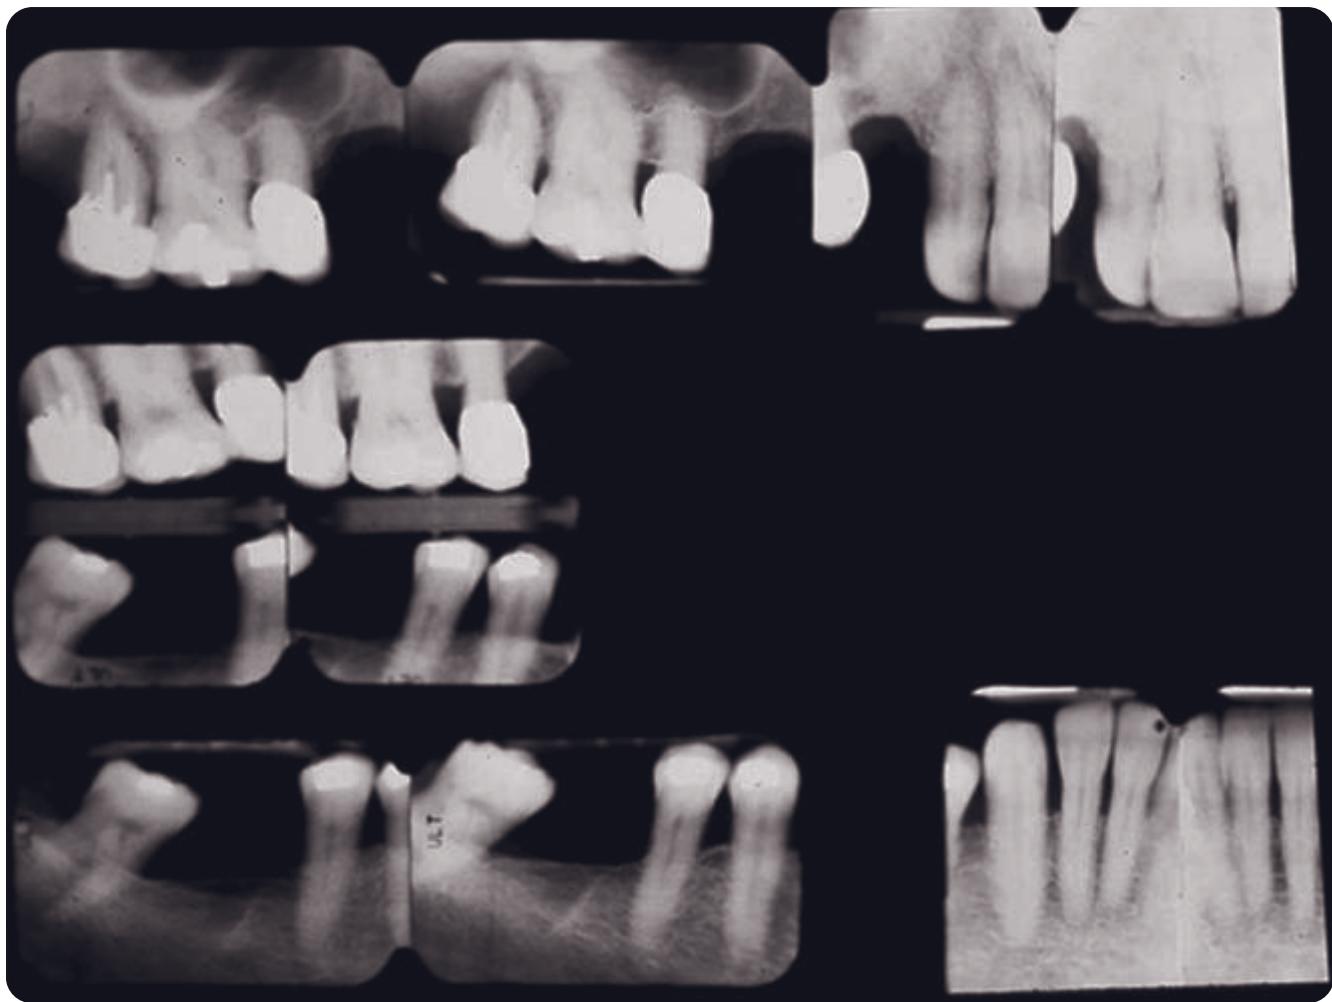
Pretreatment radiographs, right side. Note the extensive bone loss on tooth 2.
